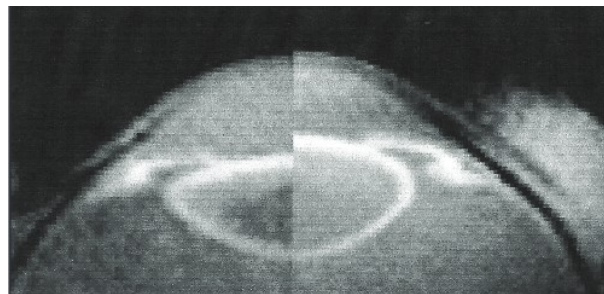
MRI of the unaccommodated eye of a 26 year old person (left) and of a 49 year old person (right). In the older eye, increased lens thickness, reduced pupil diameter and anterior displacement of the uveal tract can be detected [107] (reprinted from [108]).
